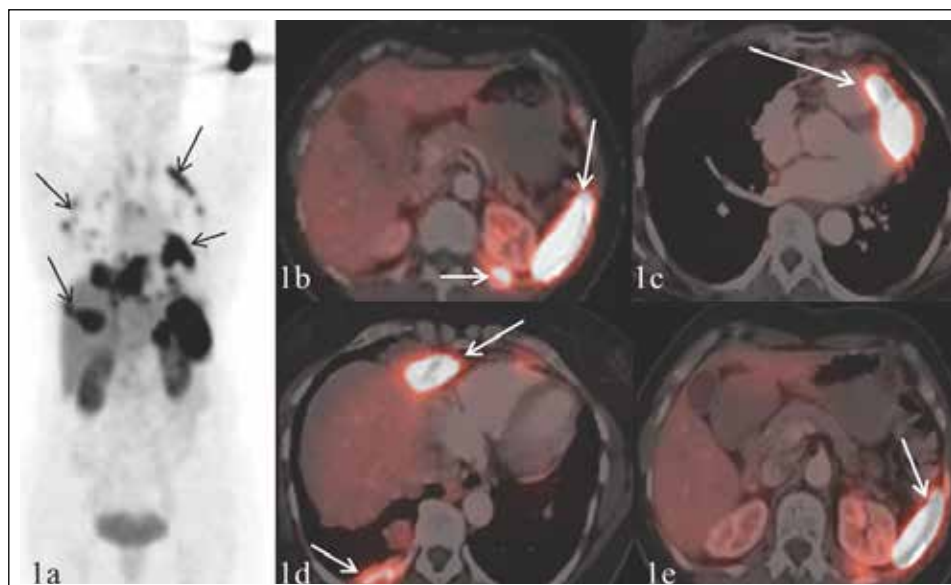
Maximum intensity projection image showing multiple foci of increased tracer uptake in the thorax (A, arrows), corresponding to pleural and pericardial metastatic deposits (B-E) on axial fused ⁶⁸Gallium DOTATOC positron emission tomography/computed tomography images.
